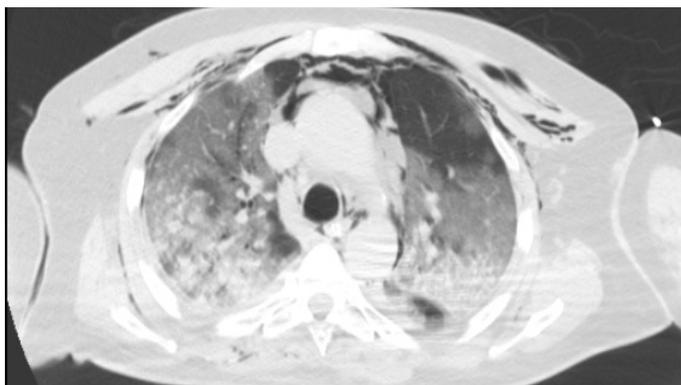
Widespread air densities in mediastinum is shown at thorax CT.
